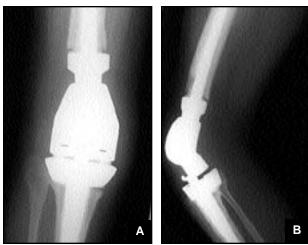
Postoperative AP (A) and lateral (B) radiographs after resection of the tumor and insertion of the custom-made prosthesis.
